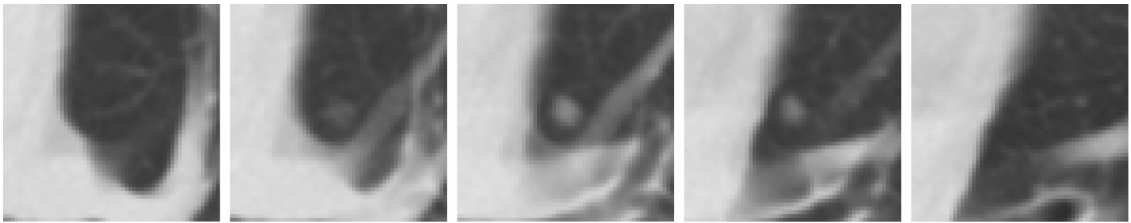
Three-dimensional characteristics of small lung nodules on pediatric MDCT images as exemplified by a nodule in our study. The nodule was clearly visible on 3 contiguous CT slices with slice thickness of 5 mm and reconstruction interval of 2.5 mm. The regions of interest (ROIs) are 30 mm in size with the nodule located centrally.
